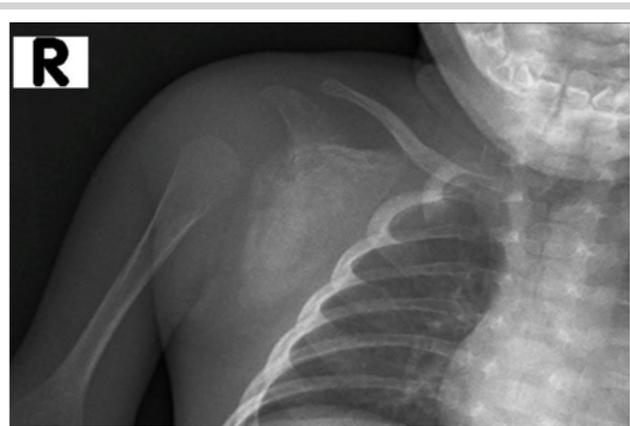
Plain X-ray - Right scapular sclerotic lesion
